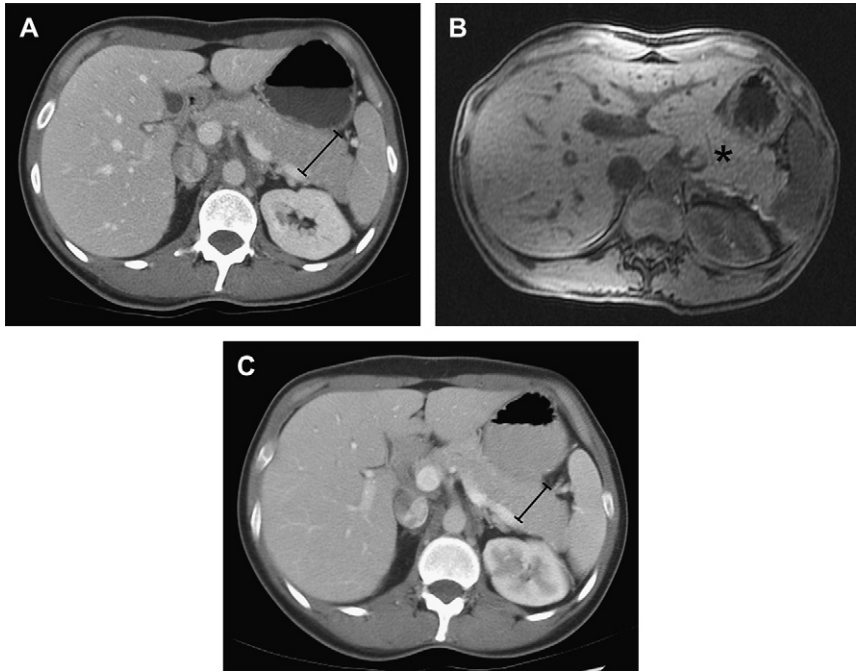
Images from a 42-year-old woman with mild abdominal pain and history of undifferentiated connective tissue disease. (A) Contrast-enhanced CT shows global pancreatic enlargement. The pancreas enhances uniformly. (B) Fat saturation T1-weighted image shows diffuse pancreatic enlargement (*asterisk*). (C) Contrast-enhanced CT performed after steroid treatment shows a decrease in size of the pancreas (compare measure bar with Fig. 1A).
